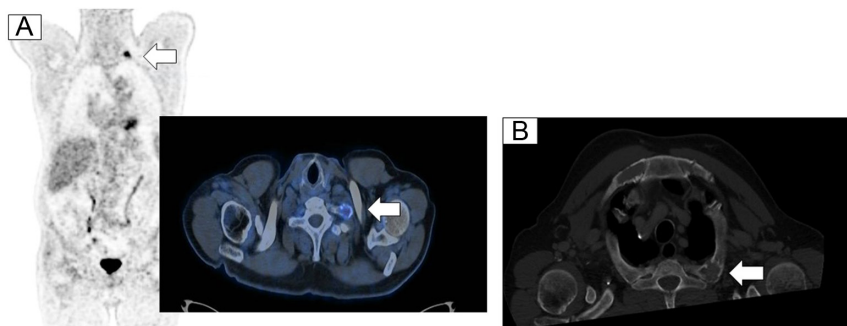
¹⁸F-FDG-based PET/CT scan (A) identifying a lesion in the first left rib as cause of TIO (SUV max 8) and thoracic CT scan (B), confirming the lesion at the first left rib. FDG, fluorodeoxyglucose.
